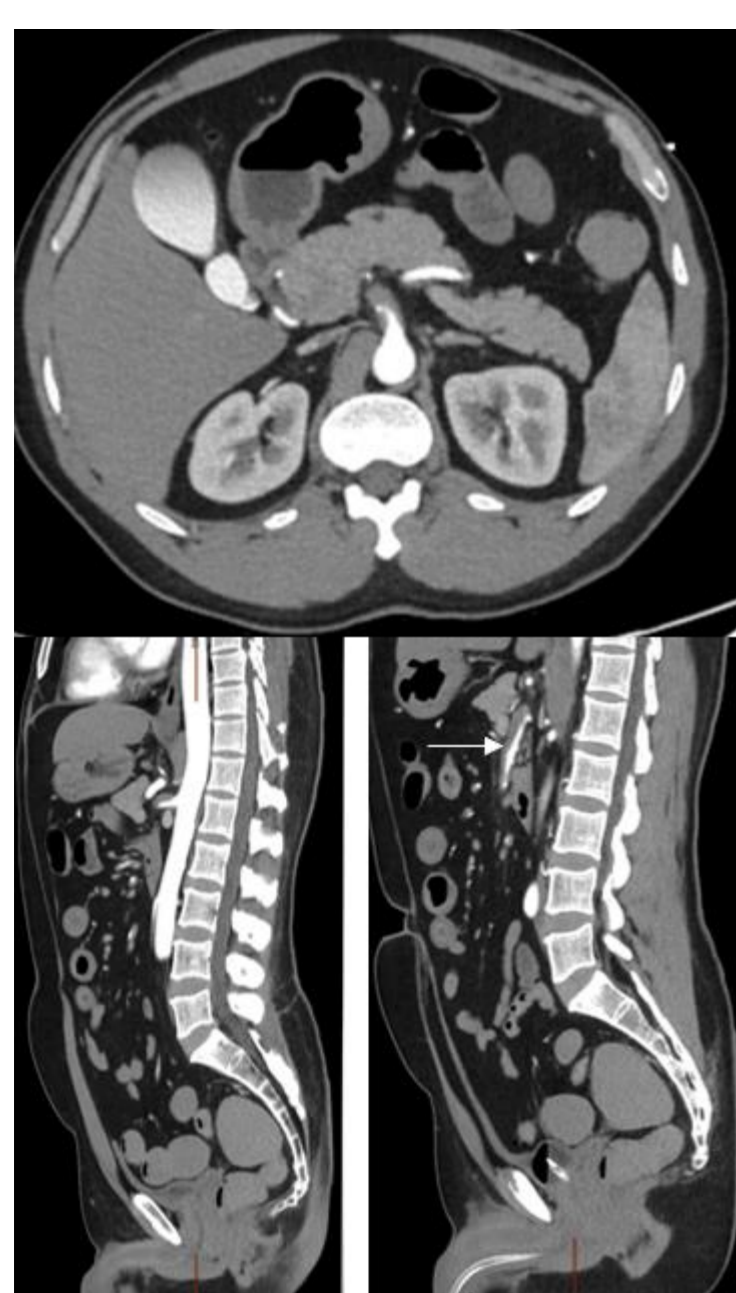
CTA showing the SMA dissection and false lumen (arrow)
